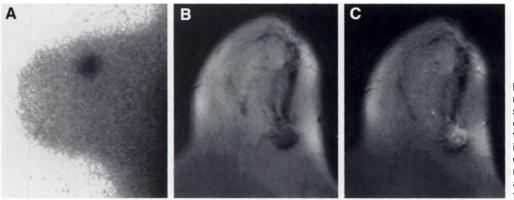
Ductal invasive breast carcinoma (pT1c). Previous mammography showed a spiculated lesion suspicious for carcinoma. (A) Scintimammography confirmed the lesion as malignant by revealing focal high sestamibi uptake. (B) Precontrast MRI showed an irregular, poorty marginated, hypointense mass. (C) After application of Gd-DTPA, marked contrast-enhancement was assessed.
